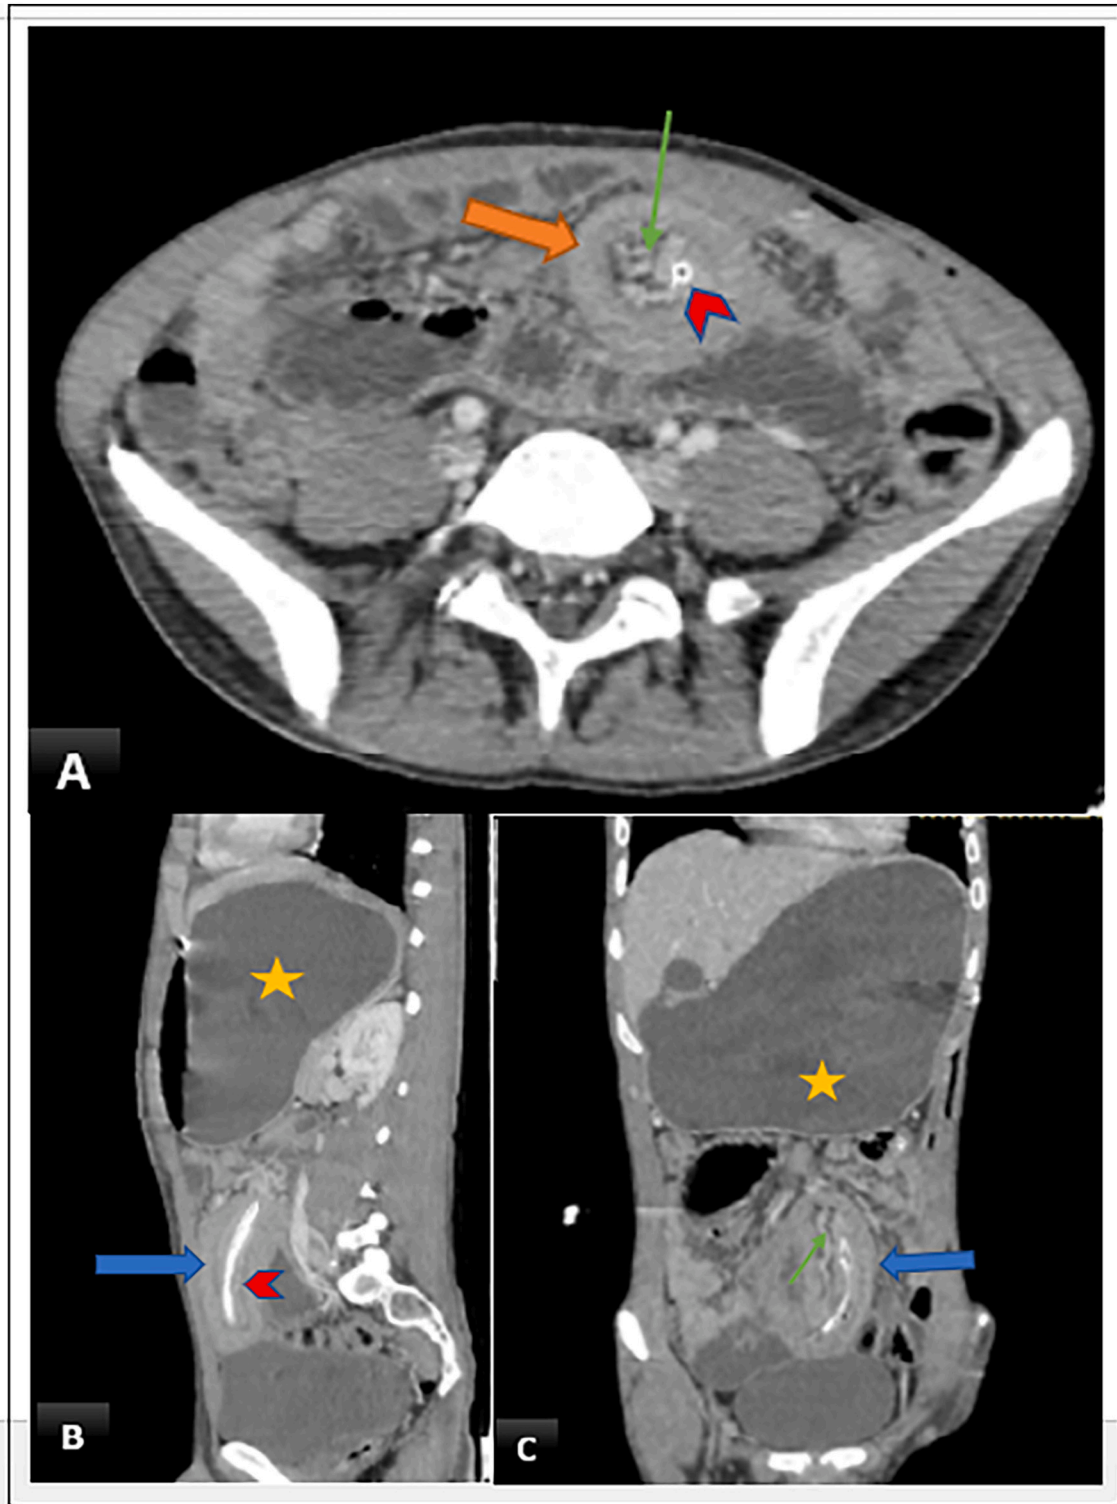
Abdominal CT scan in enhanced axial section (A); in the reconstruction of the sagittal (B) and coronal (C) section, showing a target sign of jejunojejunal intussusception (orange arrow), containing mesenteric fat and vessels (green arrow), with a jejunostomy tube in the center (head arrow), and a sausage sign in the sagittal and coronal slice (blue arrow), responsible for upstream distension.
